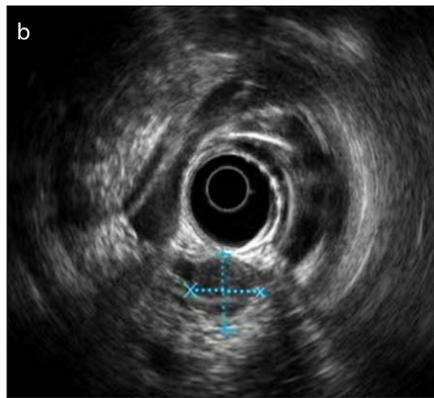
a–e. A 63-year-old woman with small duodenal GIST. Portal phase axial image of contrast-enhanced CT (a) shows a 1.9 cm round enhancing mass (arrow) in the second part of the duodenum, adjacent to the pancreas. EUS (b) shows a 1.9 cm hypoechoic lesion with irregular margins originating from the muscularis propria of the duodenum and internal color flow. Contrast-enhanced MRI also shows a 1.9 cm round enhancing mass in the second part of the duodenum on arterial phase (c, arrow), which shows low signal intensity on T1-weighted image (d, arrow) and high signal intensity on T2-weighted image (e, arrow). This was a hypervascular tumor that needed differentiation between duodenal GIST and pancreatic neuroendocrine tumor. It was proven to be an ampullary GIST in biopsy.
